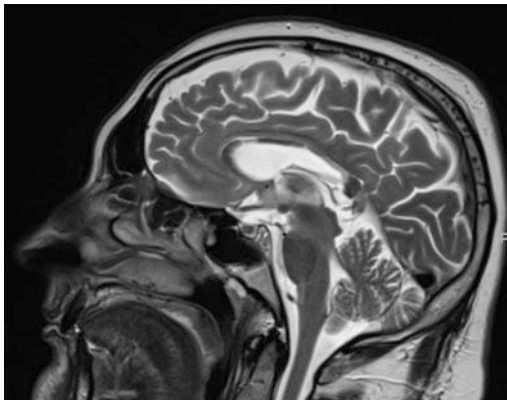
Sagittal T2-weighted magnetic resonance image showing hyperintense lesions of multiple sclerosis in the corpus callosum. Note the associated atrophy of this commissure
